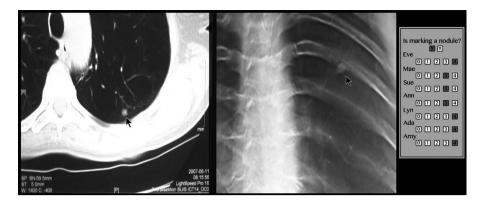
Nodule indicated with cursor arrows on the CT (left) and TS scans (right). The ratings are far right.
